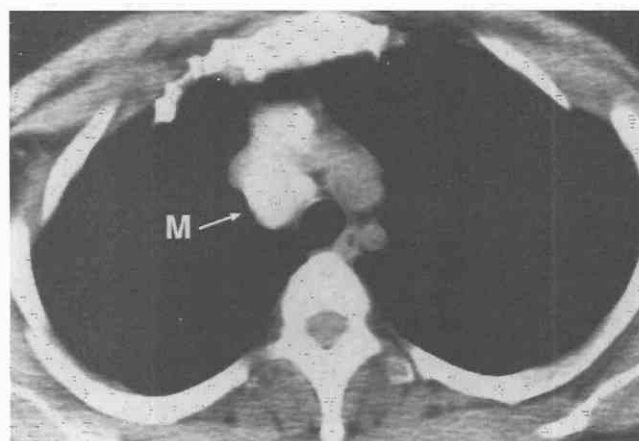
Calcified nodes. CT shows calcified right paratracheal lymph nodes (M) caused by histoplasmosis.
